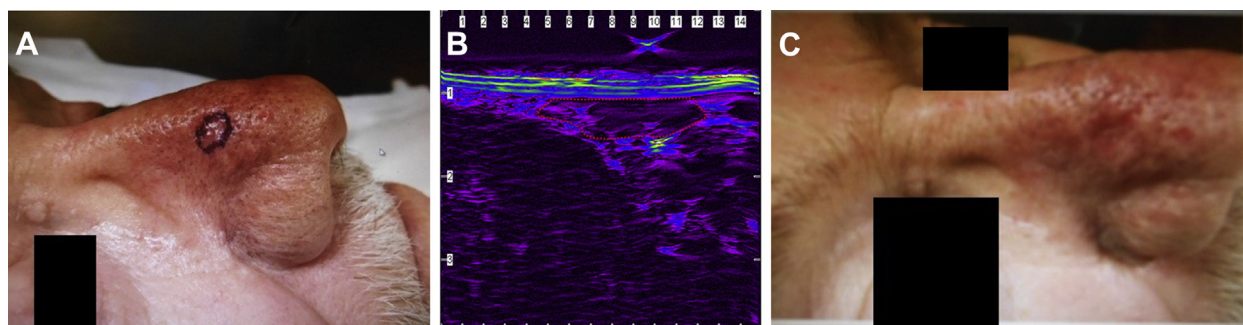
(A) Appearance of the lesion before treatment; (B) 2-dimensional ultrasound image of the lesion; and (C) appearance of the lesion 1 week after treatment completion.
